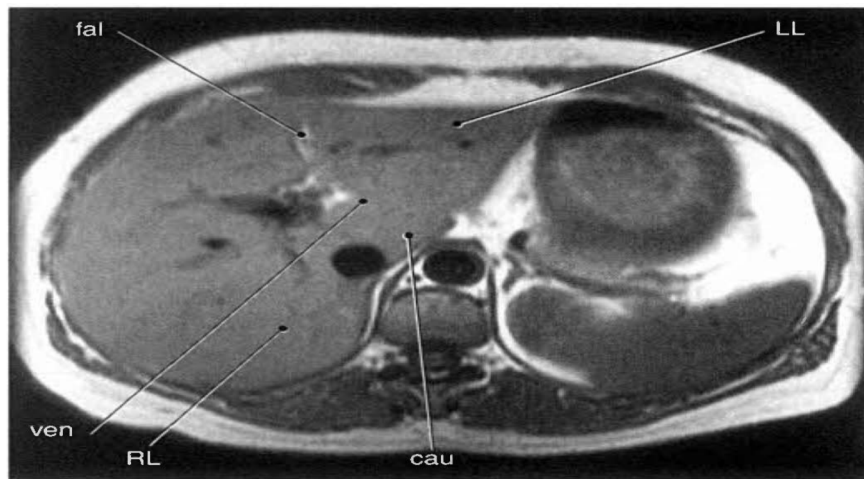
Axial, T1-weighted MR scan of abdomen with lobes of liver (Lorrie, 2007).
